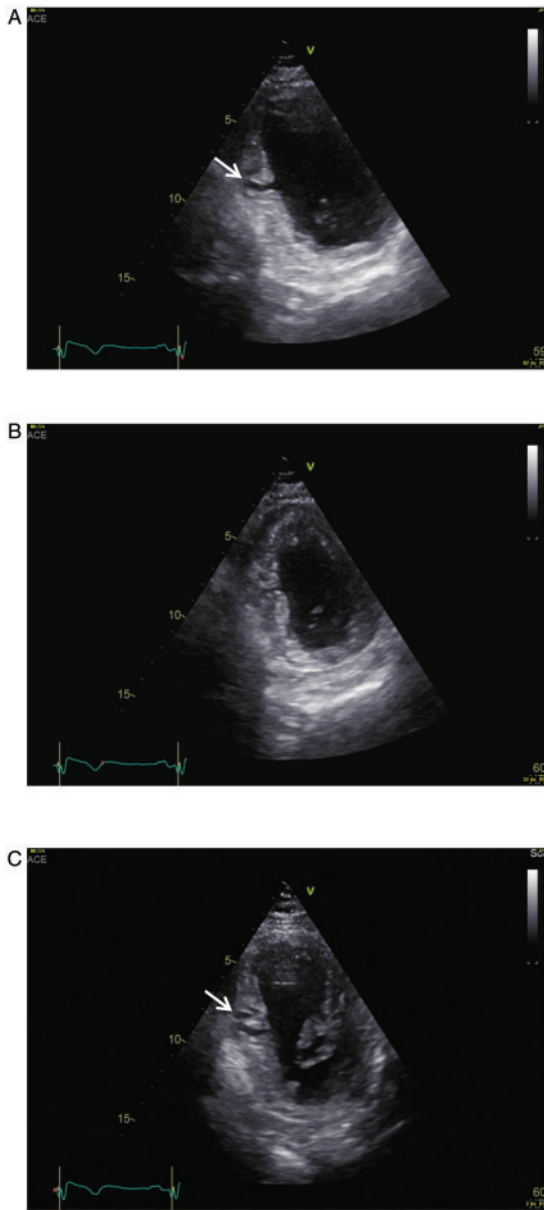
Echocardiographic features of myocardial crypts. (A) Transthoracic echocardiogram two-chamber view showing diastolic features of a myocardial crypt: penetration perpendicular to myocardial wall and contention by thin sub epicardial layer (white arrow); (B) systolic sub-total obliteration on transthoracic echocardiogram two-chamber view; and (C) modified two-chamber view demonstrates the presence of second, more apical crypt parallel of the previous one (white arrow).
